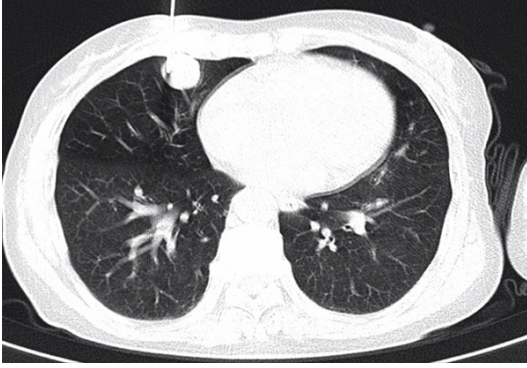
CT guided percutaneous lung biopsy of inferior lobe.
